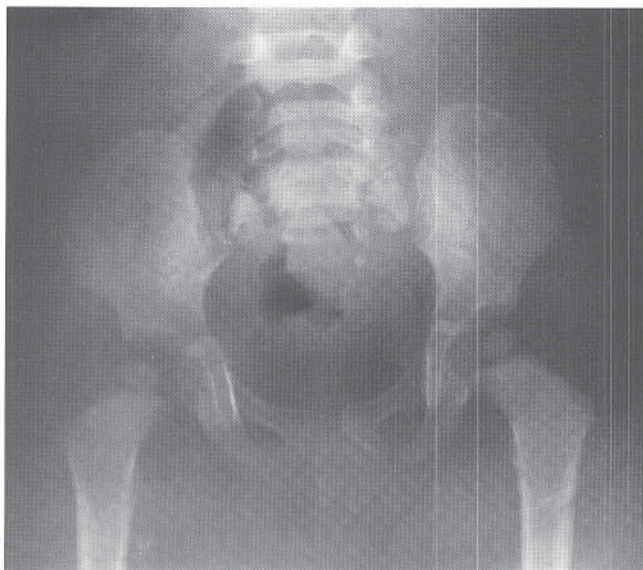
AP radiograph demonstrating subluxation of the right hip secondary to septic arthritis.
